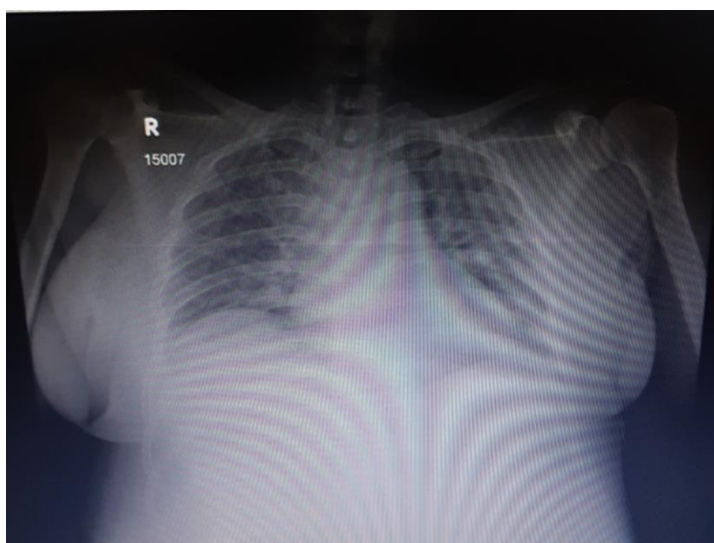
Chest X-ray showed increased bronchovascular markings and cardiomegaly.
